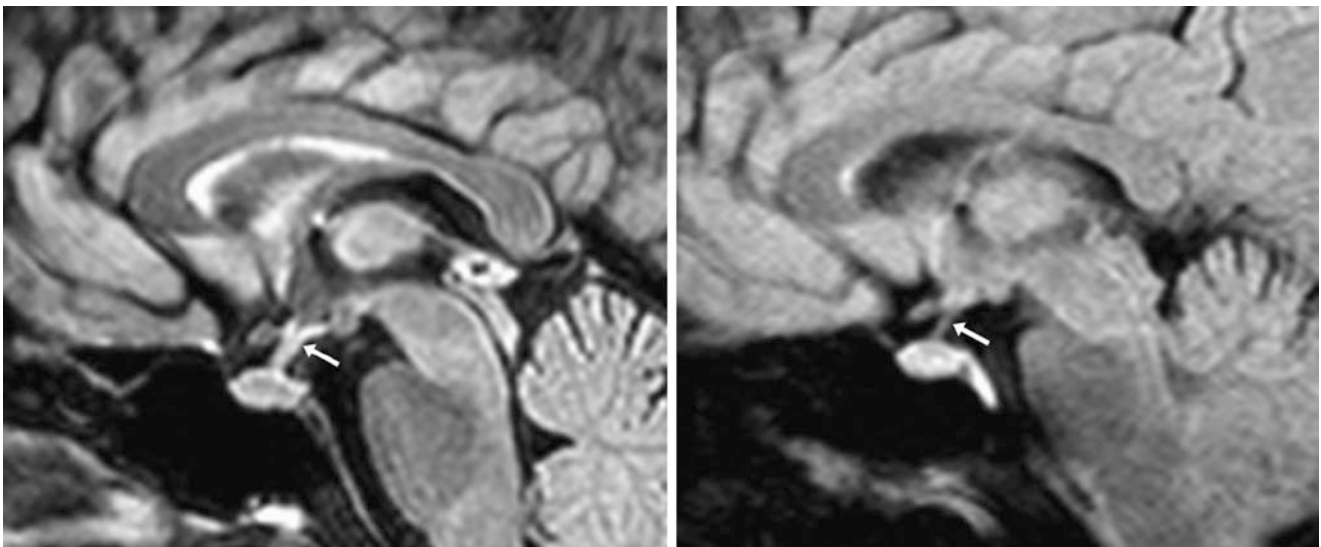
Normal infundibular hyperintensity on noncontrast three-dimensional FLAIR. In a 57-year-old female with visual symptoms (negative 3 T MRI), the infundibulum (*arrows*) is hyperintense prior to contrast
